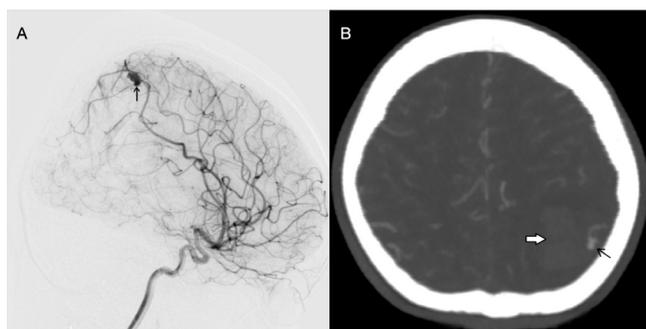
Cerebral Digital Subtraction Angiography (DSA) (A) showing bilobed saccular aneurysm (arrow) at a cortical branch of the left middle cerebral artery; and cerebral CT Angiography (B) showing the aneurysm (arrow) which has ruptured causing intraparenchymal haemorrhage (thick white arrow).
